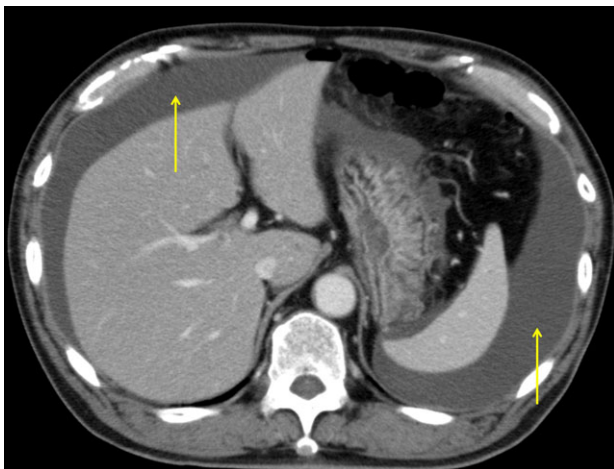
CT imaging findings of fluid collection in peritoneal cavity (arrows).
